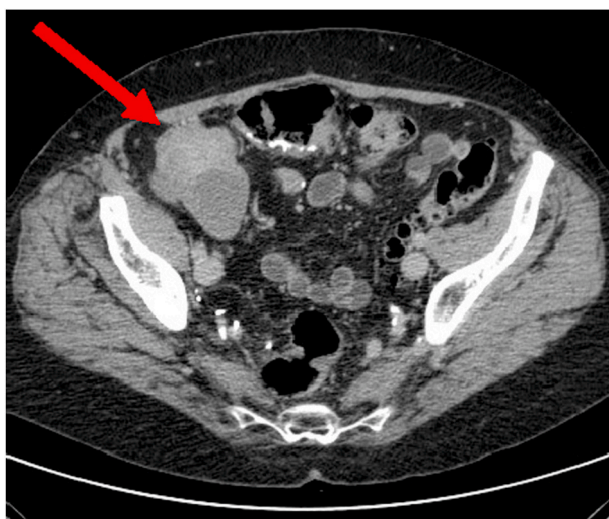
(a) and (b). CT of the abdomen and pelvis revealing a mass within the Indiana pouch colonic urinary diversion (red arrows). (For interpretation of the references to colour in this figure legend, the reader is referred to the Web version of this article.)
